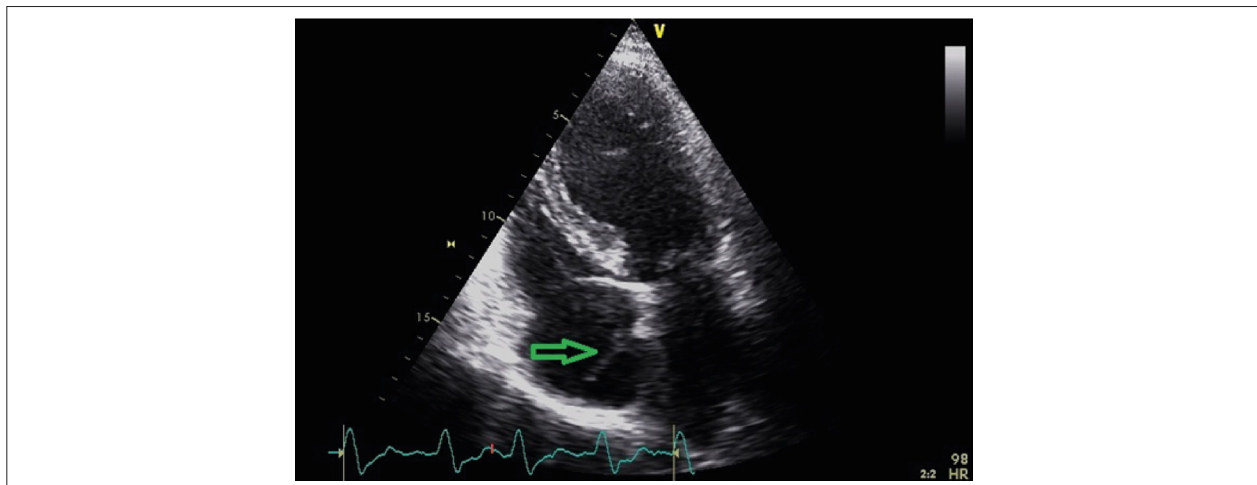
Transthoracic apical 4-chamber view showing a right atrial mass with 30mm, apparently attached to interatrial septum.
